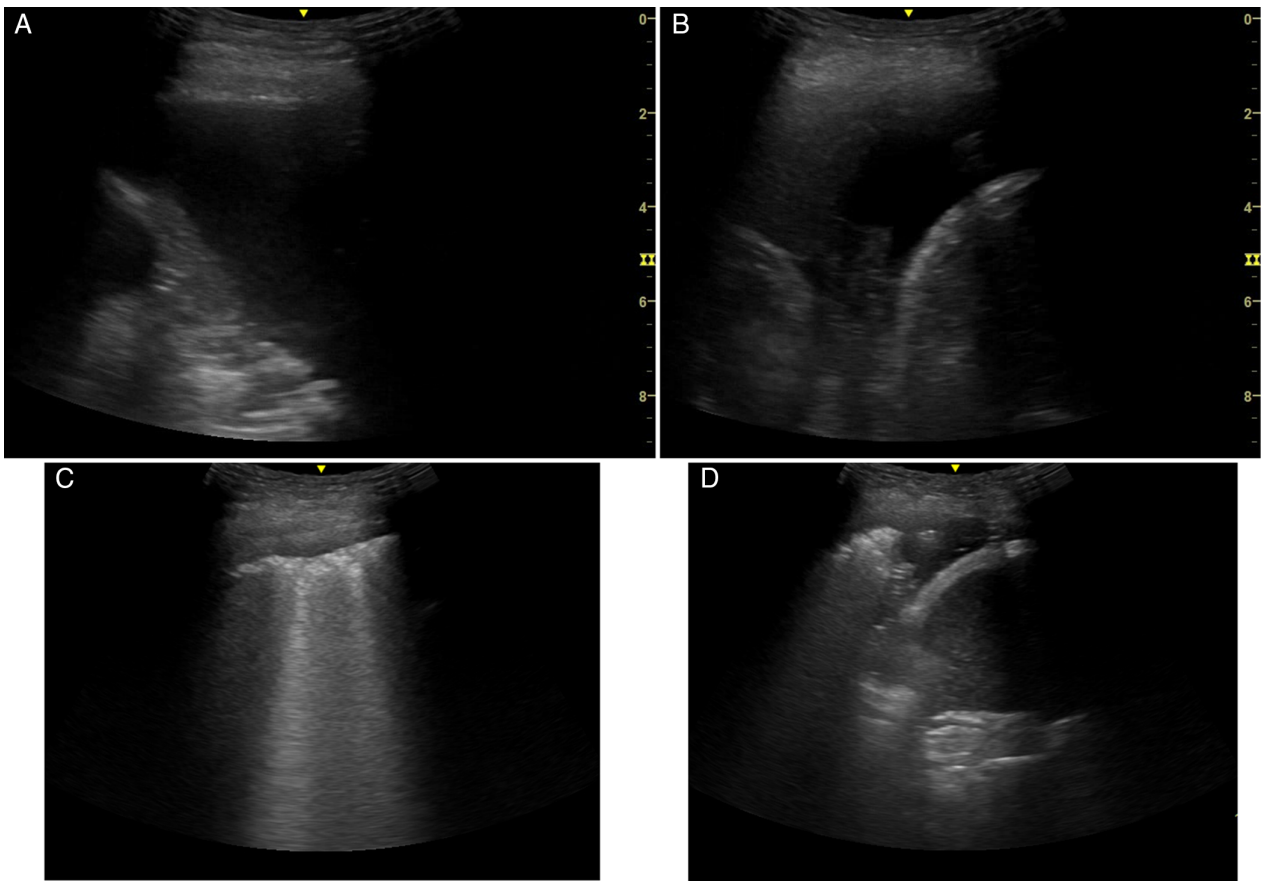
Pleural ultrasound images of an anechoic pleural effusion at mid thoracic level (A) and in the costophrenic angle (B) before use of a low-dose intrapleural tissue plasminogen activator. Ultrasound images in same locations showing lung expansion post-drainage of effusion with visible visceral pleura (C) and trivial residual effusion at the costophrenic angle (D).
